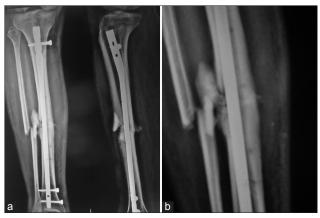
X-ray of interlocking nailing done for open mid shaft tibial fracture, (a) anteroposterior and lateral views with features of intramedullary and surface infection, (b) focused view of the same
